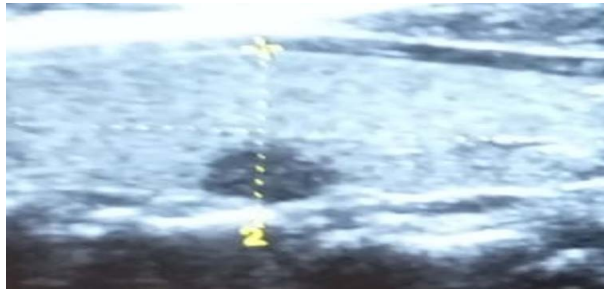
Ultrasound in longitudinal section showing a hypo-echoic lower lobar nodule with a long axis parallel to the well-defined skin plane (Ti-rads 3 examination).
